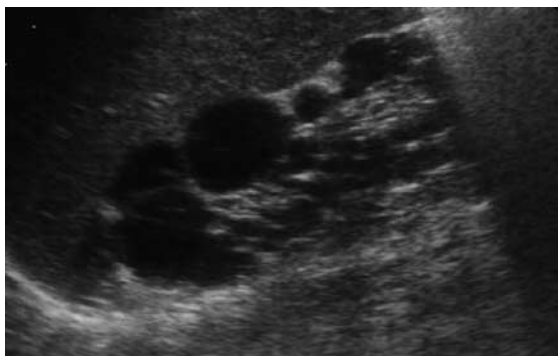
Ultrasound scan of MCDK. The image was taken from a young child with MCDK. Note the collection of non-communicating cysts (akin to 'a bunch of grapes') separated by dysplastic tissue.
